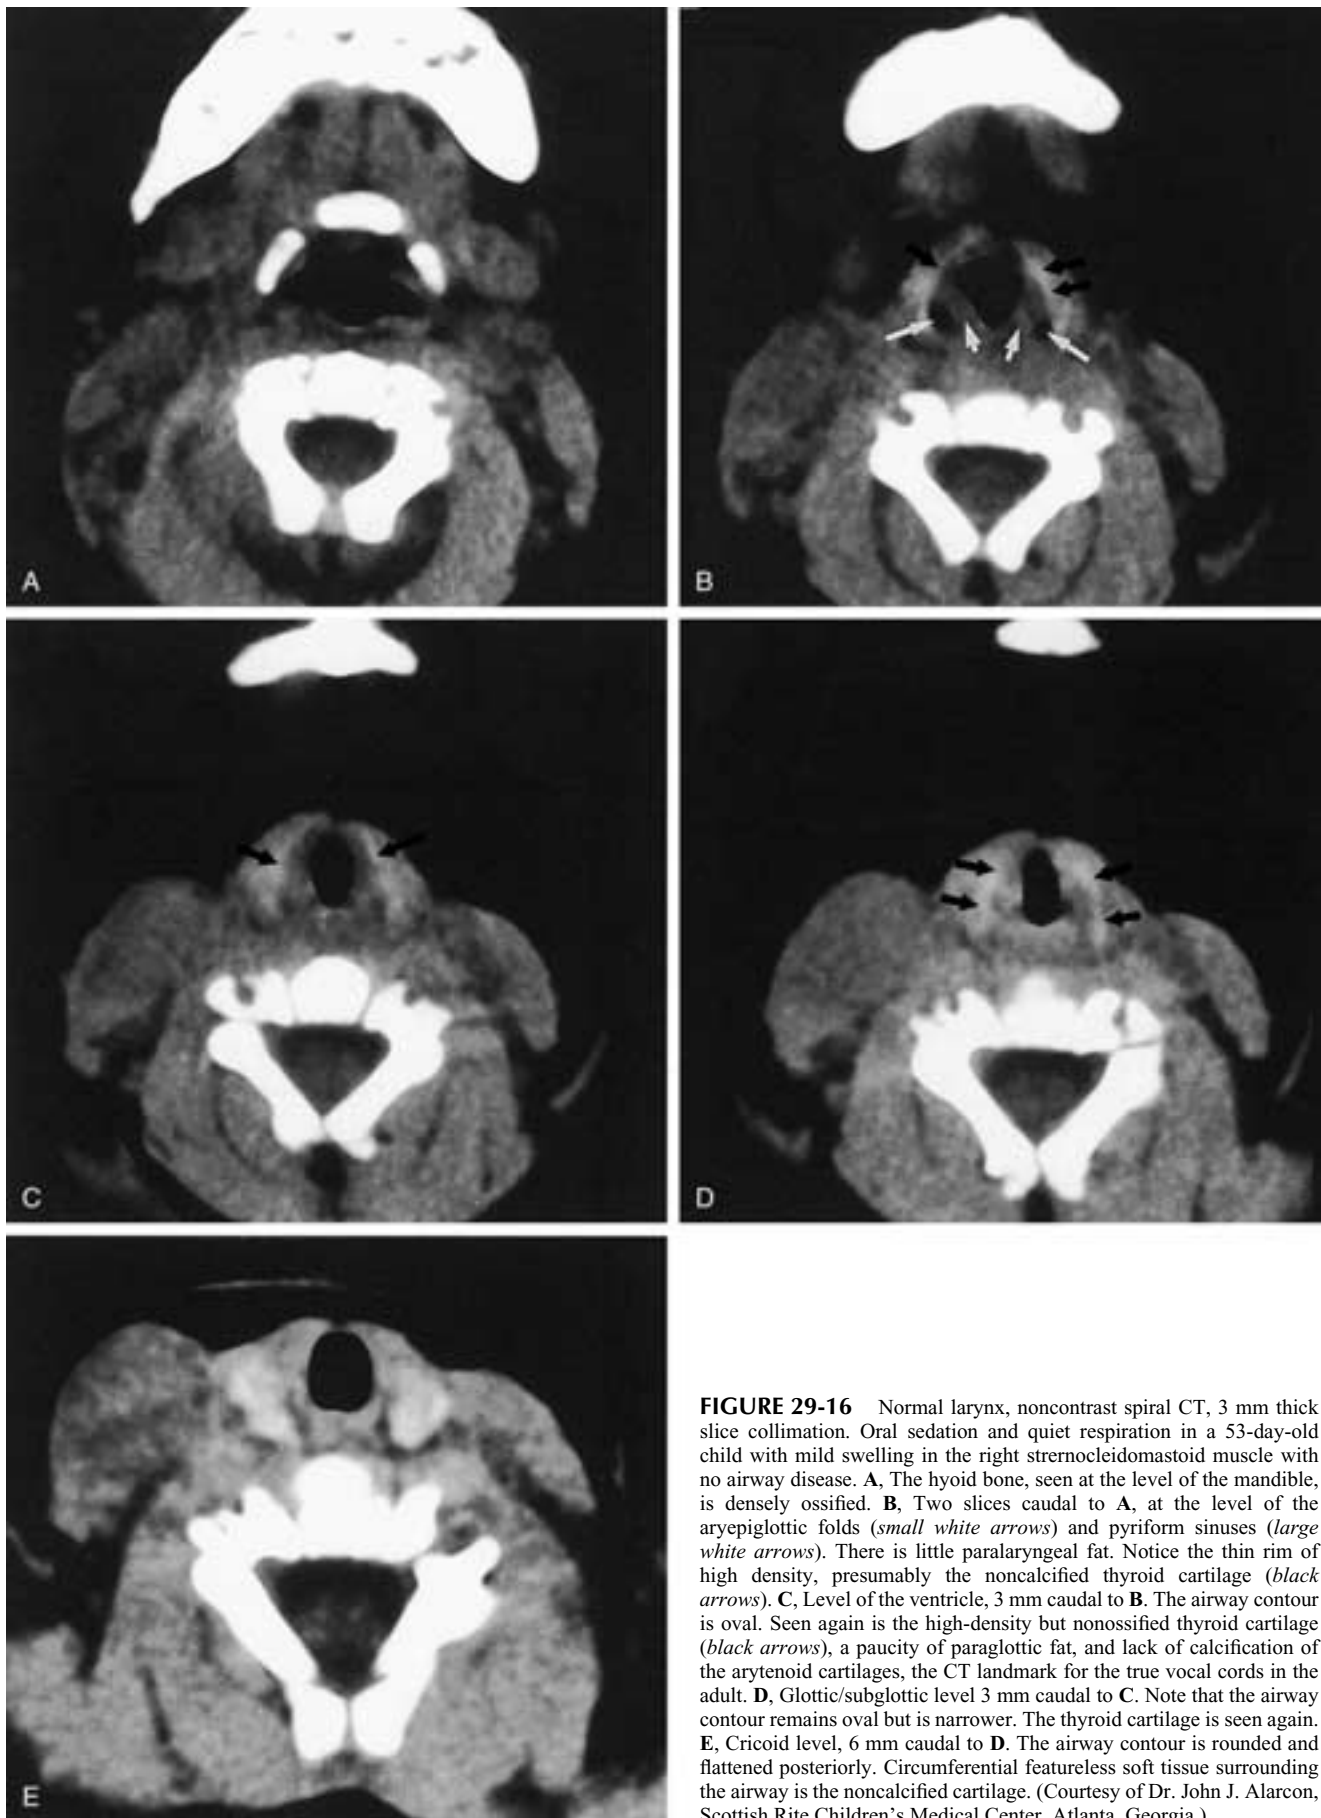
Normal larynx, noncontrast spiral CT, 3 mm thick slice collimation. Oral sedation and quiet respiration in a 53-day-old child with mild swelling in the right sternocleidomastoid muscle with no airway disease. A, The hyoid bone, seen at the level of the mandible, is densely ossified. B, Two slices caudal to A, at the level of the aryepiglottic folds (*small white arrows*) and pyriform sinuses (*large white arrows*). There is little paralaryngeal fat. Notice the thin rim of high density, presumably the noncalcified thyroid cartilage (*black arrows*). C, Level of the ventricle, 3 mm caudal to B. The airway contour is oval. Seen again is the high-density but nonossified thyroid cartilage (*black arrows*), a paucity of paraglottic fat, and lack of calcification of the arytenoid cartilages, the CT landmark for the true vocal cords in the adult. D, Glottic/subglottic level 3 mm caudal to C. Note that the airway contour remains oval but is narrower. The thyroid cartilage is seen again. E, Cricoid level, 6 mm caudal to D. The airway contour is rounded and flattened posteriorly. Circumferential featureless soft tissue surrounding the airway is the noncalcified cartilage. (Courtesy of Dr. John J. Alarcon, Scottish Rite Children's Medical Center, Atlanta, Georgia.)
